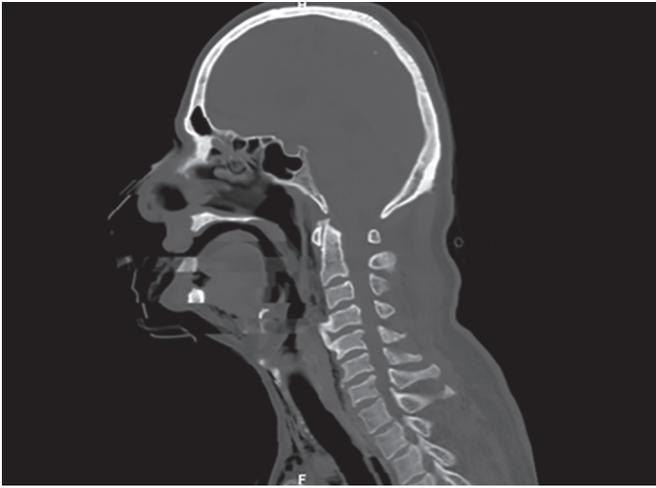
Computed tomography cervical spine sagittal section showing the prominent anterior osteophyte
